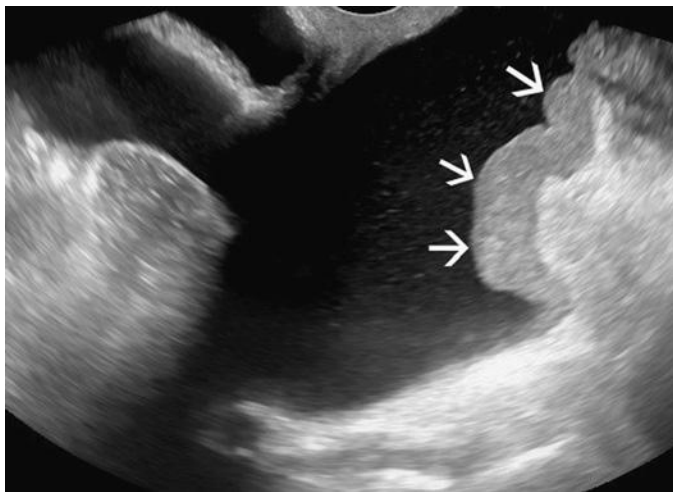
Peritoneal implants. Sagittal transvaginal ultrasound image demonstrates ascites and confluent solid peritoneal nodules (*arrows*) in the posterior cul-de-sac. This patient had metastatic serous cystadenocarcinoma of the ovary.
